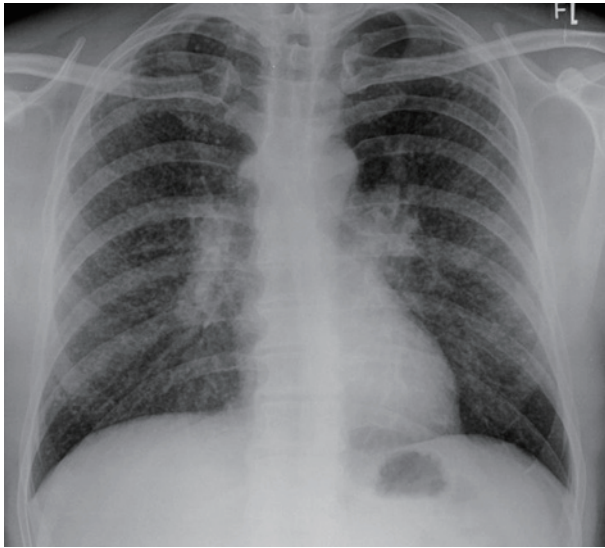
Patient's plain chest radiograph with numerous dispersed micronodules and bilateral hilar enlargement.
